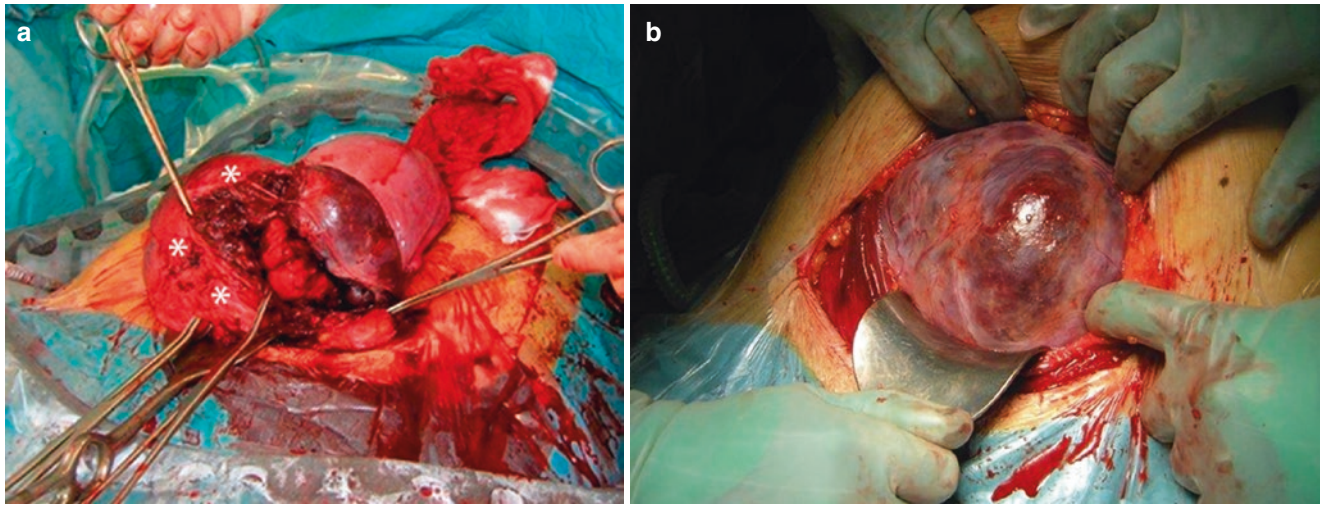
(a) Unexpected parametrial invasion (*white asterisks*) in a patient with anterior AIP. US study showed an abnormal, but not very well-defined, image on the lateral side; MRI was unavailable. In order to perform this uncommon hysterectomy, the team asked the presence of a skilled and experienced obstetrician in AIP, who solved this complicated case (Courtesy Dr. Åse Revholt, University Hospital of Northern Norway, Tromsø, Norway). (b) First viewing of precedent
